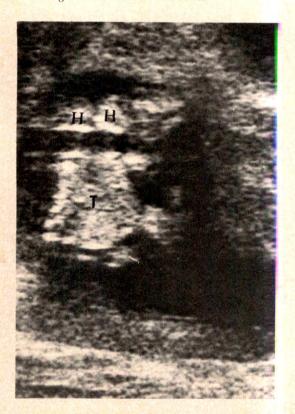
Ultrasonogram of conjoined twins at 13 weeks' postmenstrual age, showing heads (*H*) and thorax (*T*).
